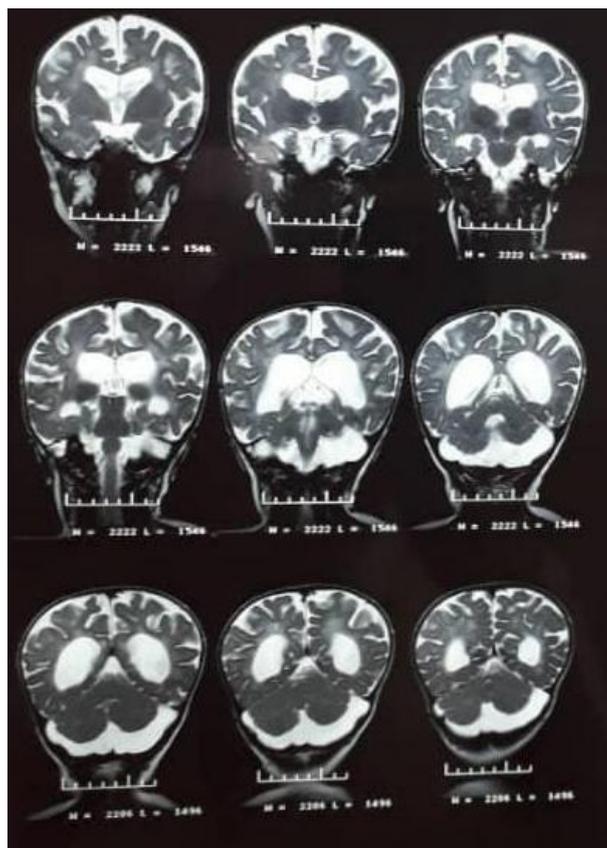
MRI: Abnormal signal intensity and generalized loss of the white matter, thin corpus callosum and diffuse cerebellar atrophy. These findings were compatible with leukodystrophy
